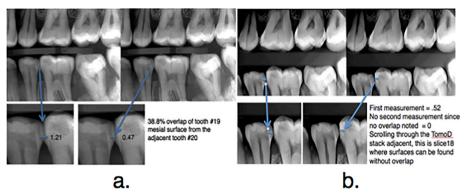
Example measurement for of standard bitewing and s-IOT generated images. s-IOT, stationary intraoral tomosynthesis.
